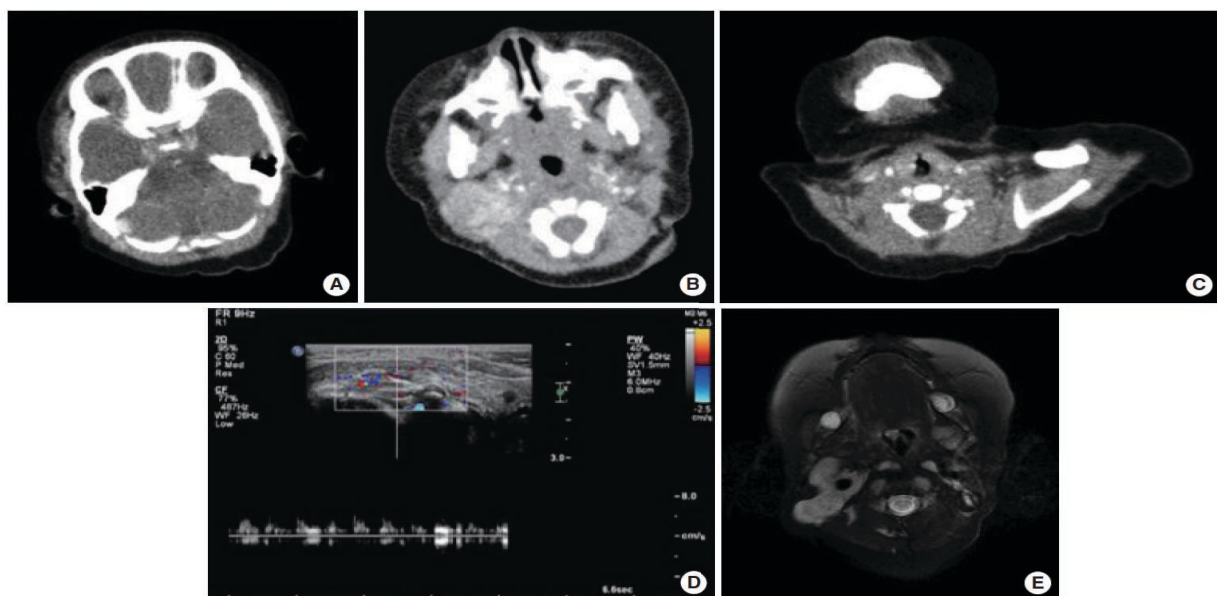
(A) Computed tomography (CT) image shows diffuse ill-defined, well-enhancing mass-like lesion at the parietal area. Panels B and C are continuous CT images, lesion was seen to extend to the thoracic inlet, causing a mass effect on the airway. (D) Soft tissue ultrasonography shows a hypoechoic mass-like lesion with prominent internal vascularity (venous flow noted) in the right posterior neck muscular layer which was posterior to the parotid gland. (E) Magnetic resonance image (MRI) shows a T2-weighted image high signal lesion in the right posterior neck area, including a right carotid space and posterior cervical space.
